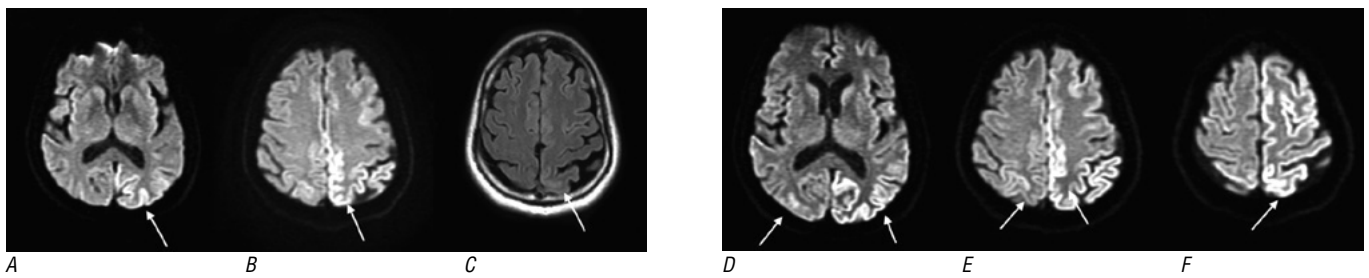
Brain MRI (axial section, diffusion-weighted images; *A, B*) performed during the initial admission shows left occipito-parietal and parafalcine gyri form diffusion restriction (arrows). *C* – T2 FLAIR hyperintensity in the corresponding areas; *D–F* – subsequent brain MRI (diffusion-weighted sequences, axial section) done during the next admission show an increase of the gyriform diffusion restriction to involve the contralateral hemisphere and high frontoparietal region, sparing the perirolandic cortex.
